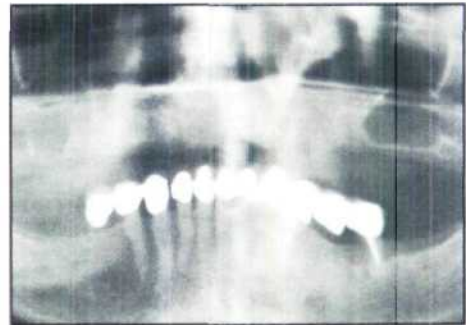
Radiograph of the metal-ceramic fixed splint, which was in place for 7.5 years.
